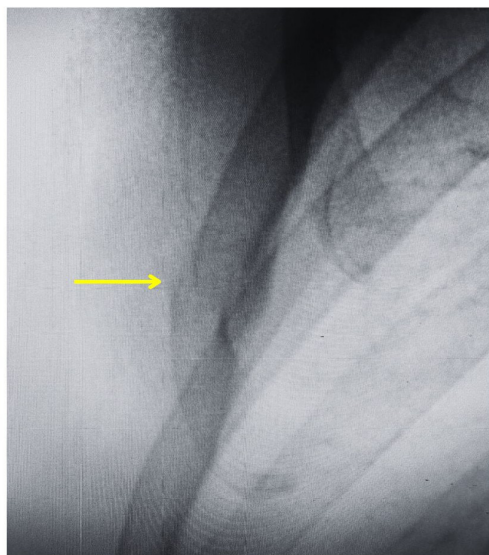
Oblique view chest Xray showing the rib fracture (yellow arrow)
